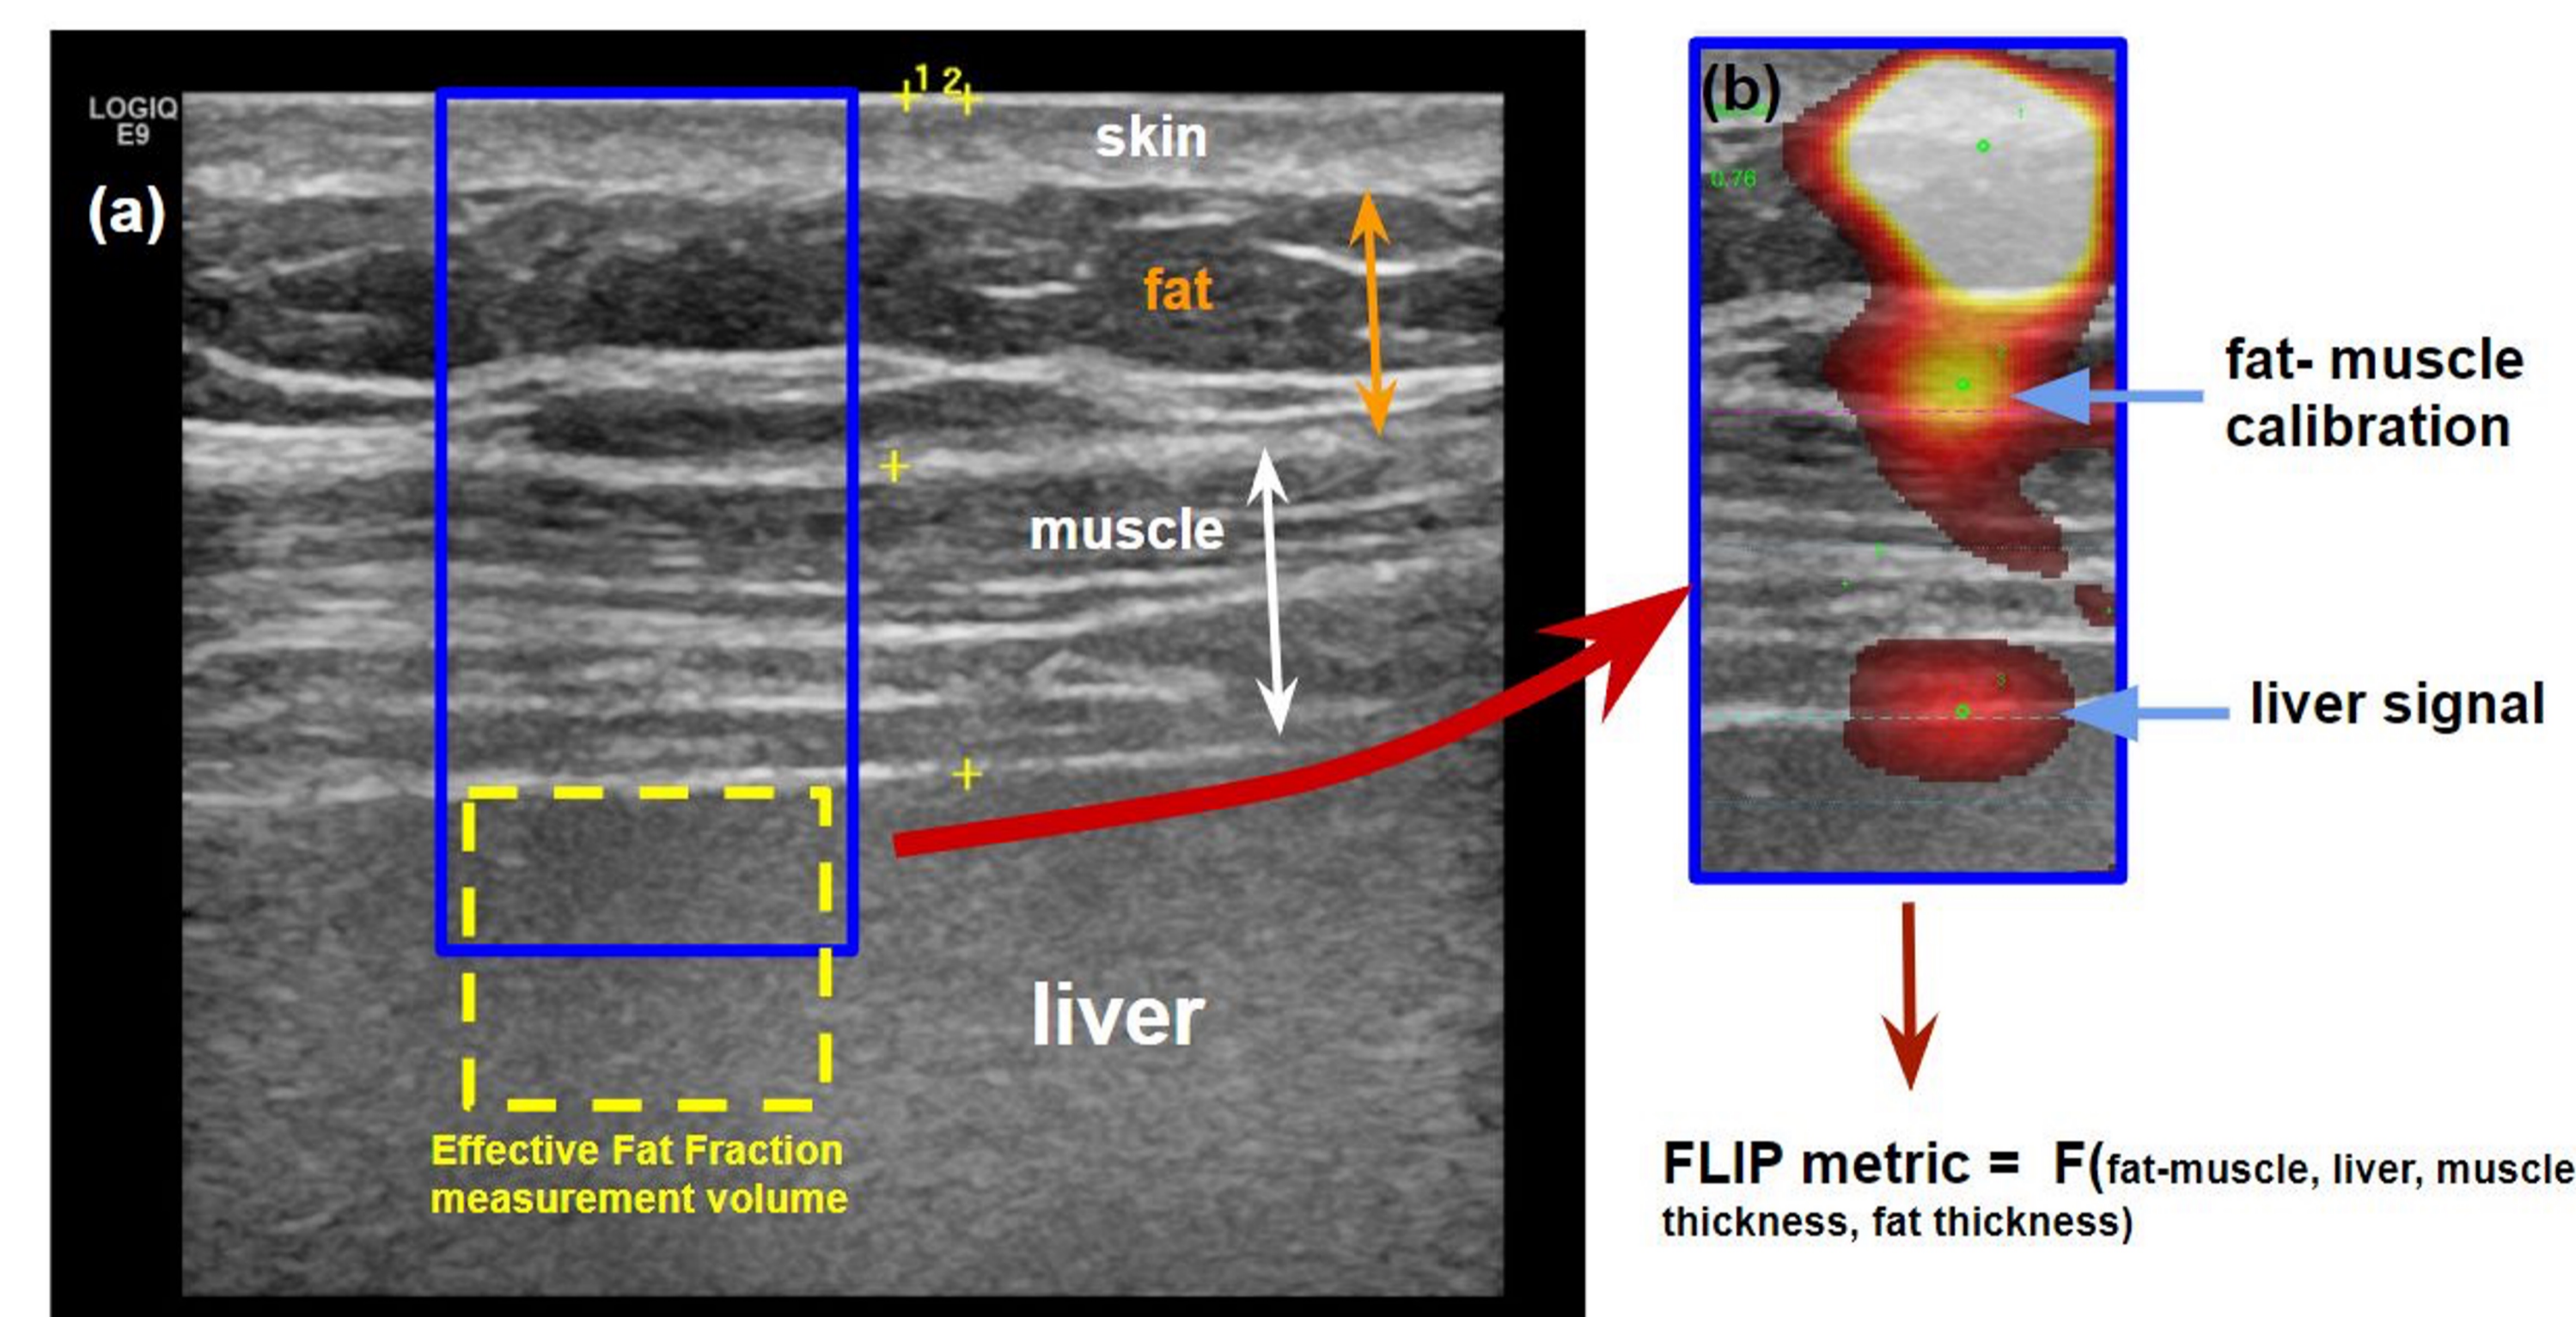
Conventional ultrasound images obtained with a linear probe are able to delineate the relevant tissue structures in measurement location (skin, subcutaneous fat, intercostal muscle, and liver). The liver tissue measurement is obtained from a 16mm cylindrical region below the liver capsule as shown in (a) with the yellow dashed box. The thermoacoustic calibration and liver signals are shown in (b) overlaid onto the conventional ultrasound image. The FLIP metric incorporates acquired thermoacoustic signals and patient specific tissue depths.
